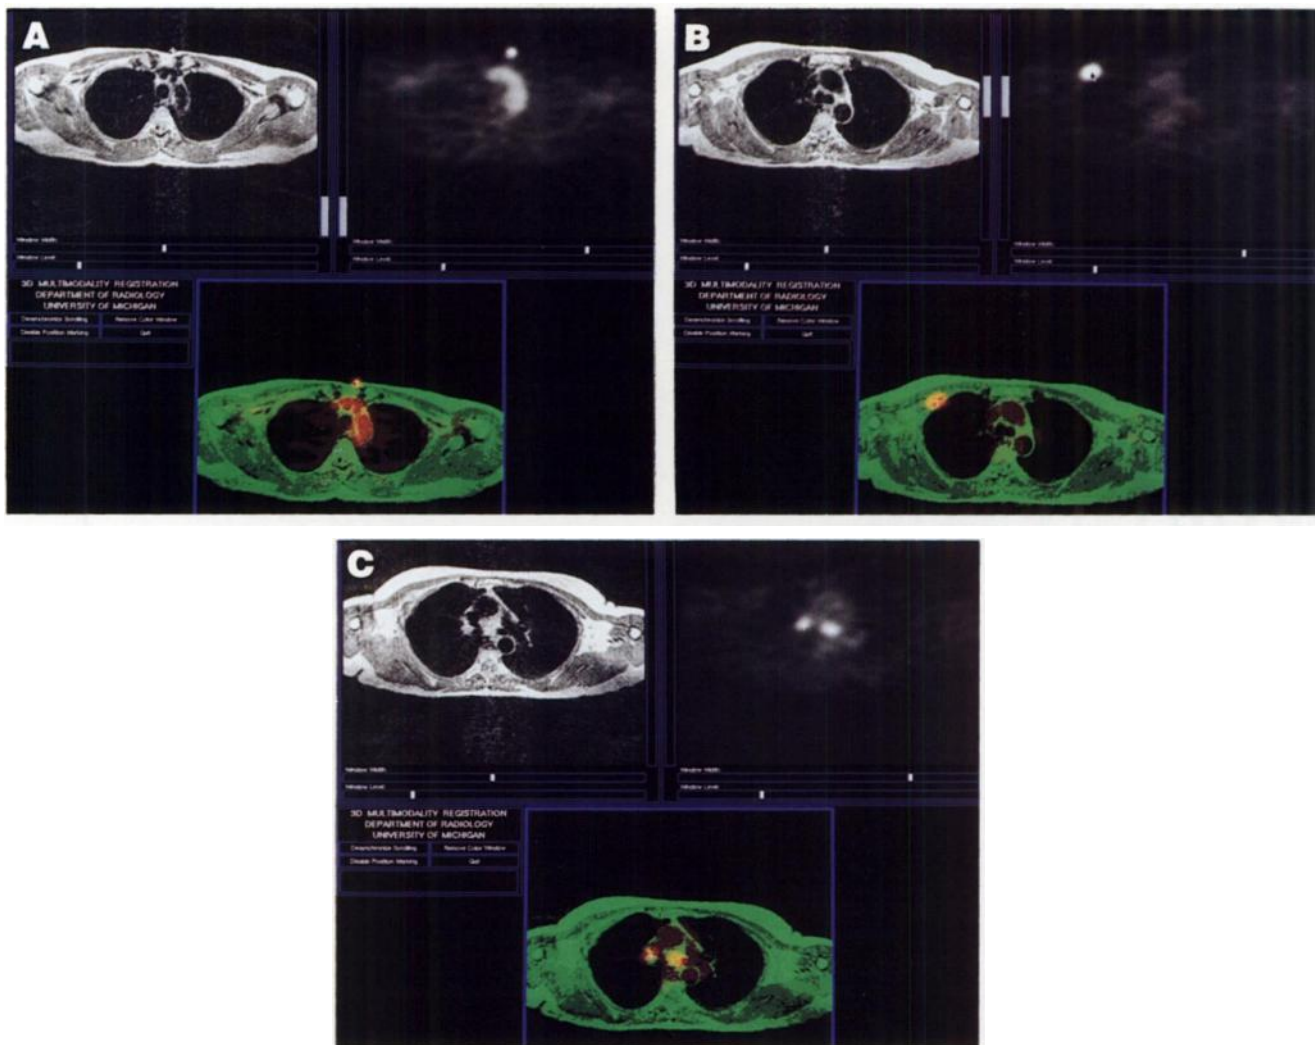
(A) Images of the upper chest in a woman with metastatic breast cancer show a marker over the upper sternum on both proton-density (TR 2600, TE 30) MR (upper left) and emission PET (upper right). PET shows residual FDG activity in the blood vessels (windowed to allow vessel visualization at 60 min postinjection). Fusion image (bottom) shows excellent registration between the FDG marker on emission PET and the vitamin E marker on MRI. Direct superimposition of the blood-pool FDG activity onto MRI-defined upper thoracic blood vessels is seen. (B) At a somewhat lower level, an intense focus of FDG uptake is noted in the right anterior chest region. This focus is difficult to localize on emission PET alone, due to its high target-to-background ratio, and could represent either chest wall or a possible axillary lymph node focus of increased FDG activity. Proton-density MRI demonstrates focal expansion and distortion of an anterior right rib. The fusion image superimposes intense FDG uptake into this abnormal rib, which is consistent with an FDG-avid rib metastasis. (C) Two foci of intense FDG uptake were also seen in the mediastinum of this patient on emission PET (upper right). Proton-density MRI of this area was interpreted as essentially normal (upper left). The fusion image placed the increased FDG uptake into borderline normal-sized lymph nodes (lower image). Eight months postscanning, the patient had CT, which demonstrated progressive breast cancer in multiple locations, including the mediastinum. Thus, clinical follow-up strongly suggests that FDG uptake was in borderline normal-sized, but tumor-involved, lymph nodes.
